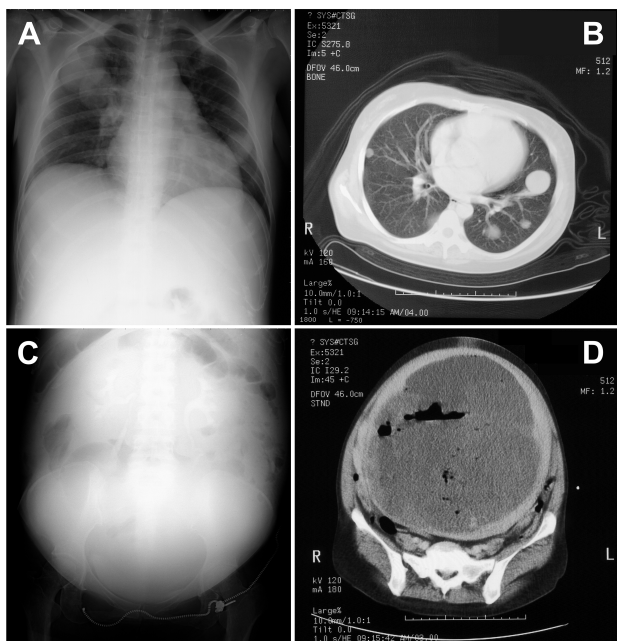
Imaging findings on admission. Chest X-p (A) and computed tomography (CT) (B) images show multiple lung metastases. Abdominal X-p shows an extensive abdominal tumor (C). CT shows an intra-abdominal tumor with an air-fluid level (D).
